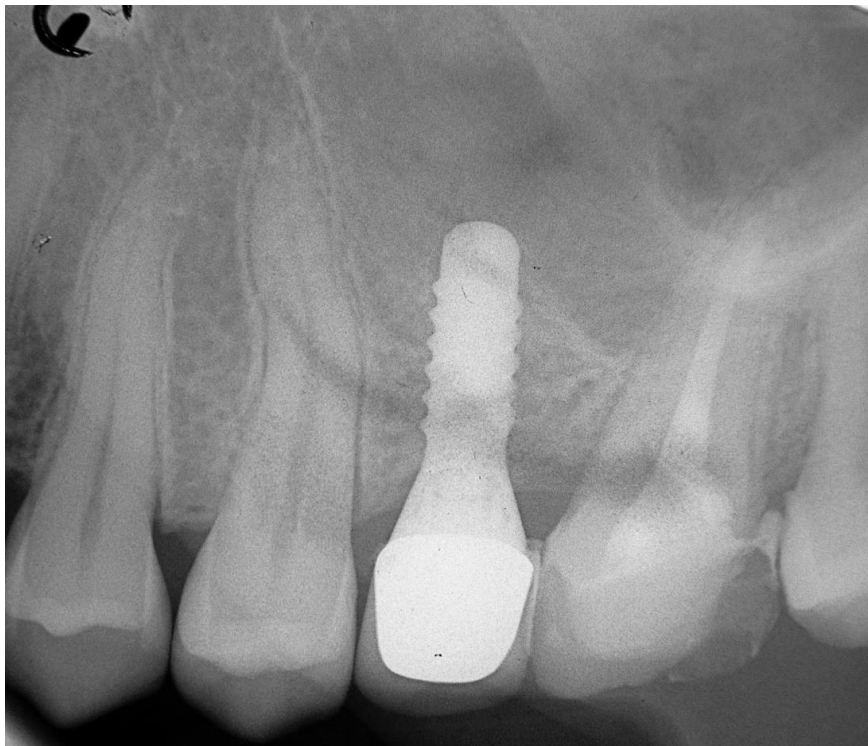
X-ray 36 month after prosthesis.
